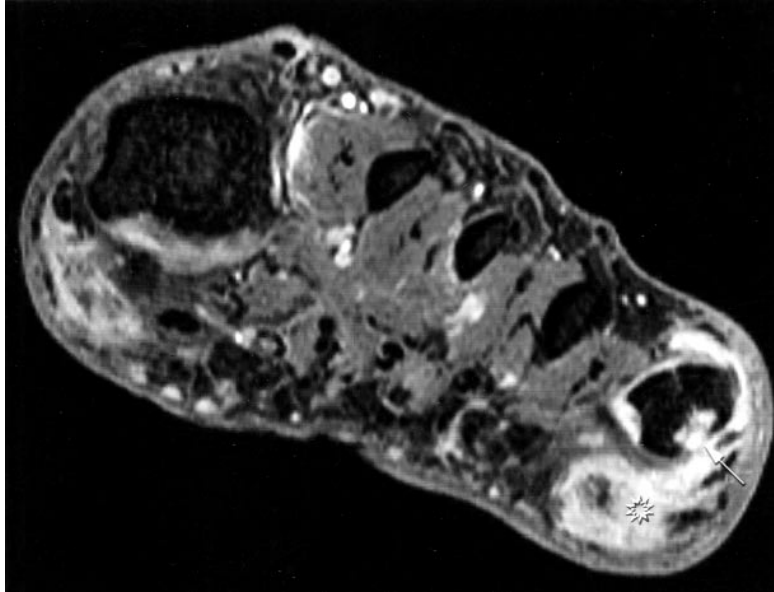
Axial fat suppressed gadolinium enhanced 3D FLASH MR image in a 69-year-old woman with RA shows an osseous erosion on the lateral aspect of the 5th MTP joint (arrow) associated with synovitis. Note the presence of bursitis beneath the 5th metatarsal head (star) and to a lesser degree beneath the 1st metatarsal head.
